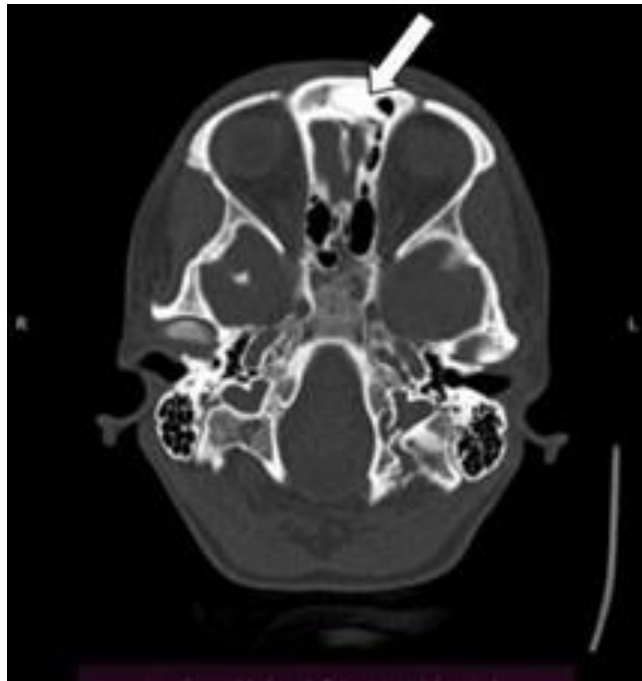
Axial view of a CT scan showing osteoid osteoma in right and left Frontal sinuses (white arrow).
